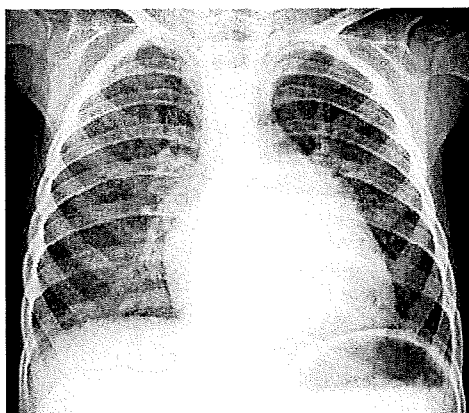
Chest radiograph shows a cardiothoracic ratio of 56%, with a double right cardiac silhouette produced by a markedly enlarged left atrium.
